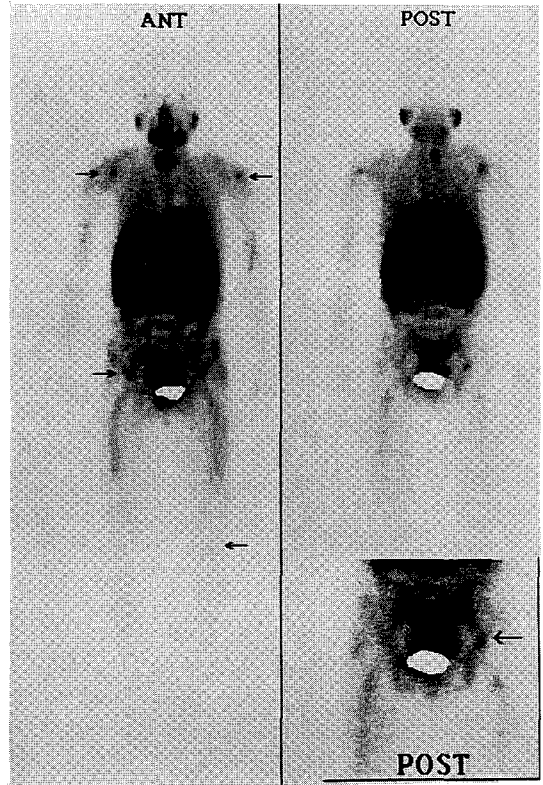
Whole body scintigraphy using ^{99m}Tc-MIBI reveals mild increased uptake in left knee, both shoulders and right acetabulum (arrows). Iliac lesion on the right is shown in insert (right lower corner).
